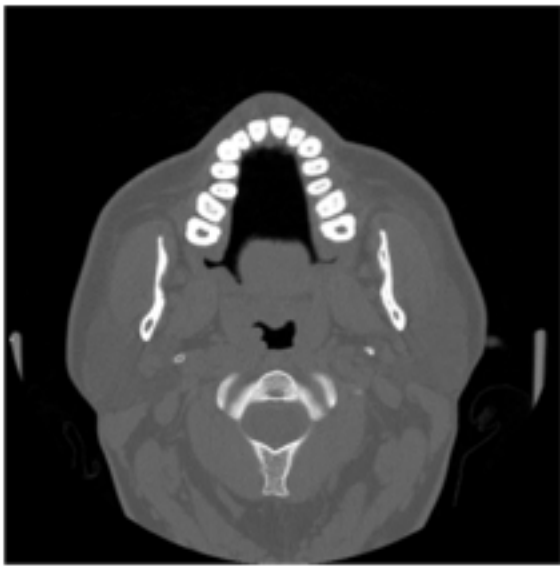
Preoperative spiral computed tomography scan showing single root and single canal with 17 and 27
